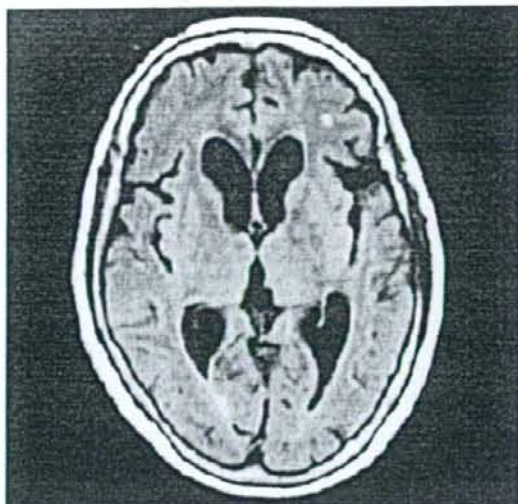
Case 2: Brain CT scan 2 months after injury.
